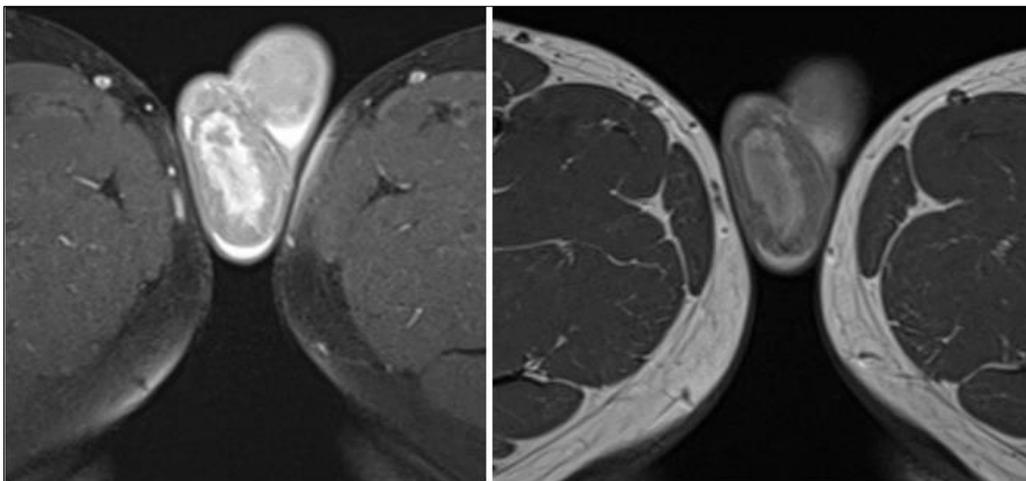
Testicular MRI: Signal abnormality in moderate hypersignal seat of zone in frank hyposignal on the T1 and T7 sequence not enhanced after injection of gadolinium
